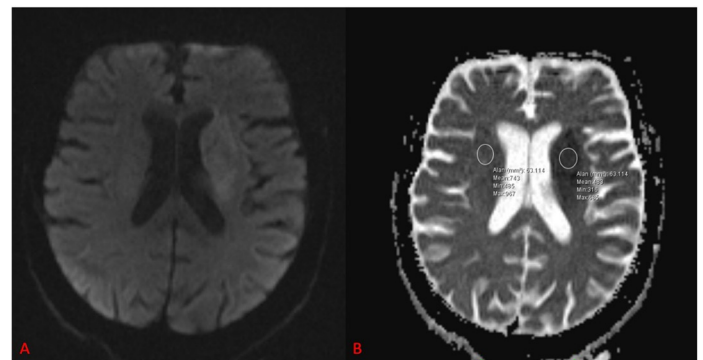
Representative diffusion-weighted magnetic resonance imaging (DWI) and corresponding apparent diffusion coefficient (ADC) map from a patient with acute ischemic stroke. A circular region of interest (ROI) was manually placed within the infarct core on the ADC map (left), and a symmetric ROI of identical size was placed in the contralateral hemisphere (right). These ROIs were used to calculate interhemispheric ADC differences. ADC values are expressed in $\times 10^{-6}$ mm²/s
